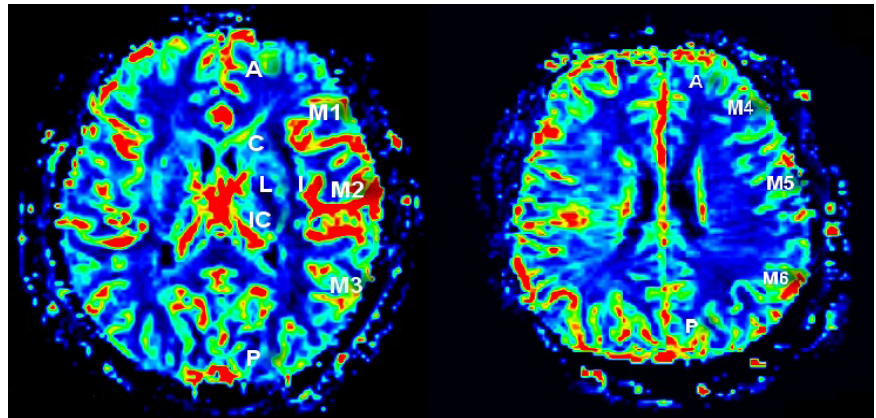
According to the Alberta Stroke Program Early Computerized Tomography Score (ASPECTS) study [12], a normal CT scan of the territory of the middle cerebral artery (MCA) is allotted ten points: cortical regions supplied by the MCA are allotted seven points (one point for insular cortex, M1, M2, M3, M4, M5, and M6), whereas subcortical structures are allotted with three points (one point for C, L, and IC). One point is subtracted for an area of early ischemic change, such as focal swelling, or parenchymal hypoattenuation, for each of the defined regions. A score of zero indicates diffuse ischemia throughout the territory of the MCA. Legend: A, anterior cerebral circulation (blood supplied by anterior cerebral artery); P, posterior cerebral circulation (blood supplied by posterior cerebral artery); C, caudate; L, lenticular nucleus; IC, internal capsule; I, "insular ribbon"; M1, anterior MCA cortex; M2, MCA cortex lateral to the insular ribbon; M3, posterior MCA cortex; M4, M5 and M6 correspond to the anterior, lateral and posterior MCA territories immediately superior to M1, M2, and M3, rostral to basal ganglia.
